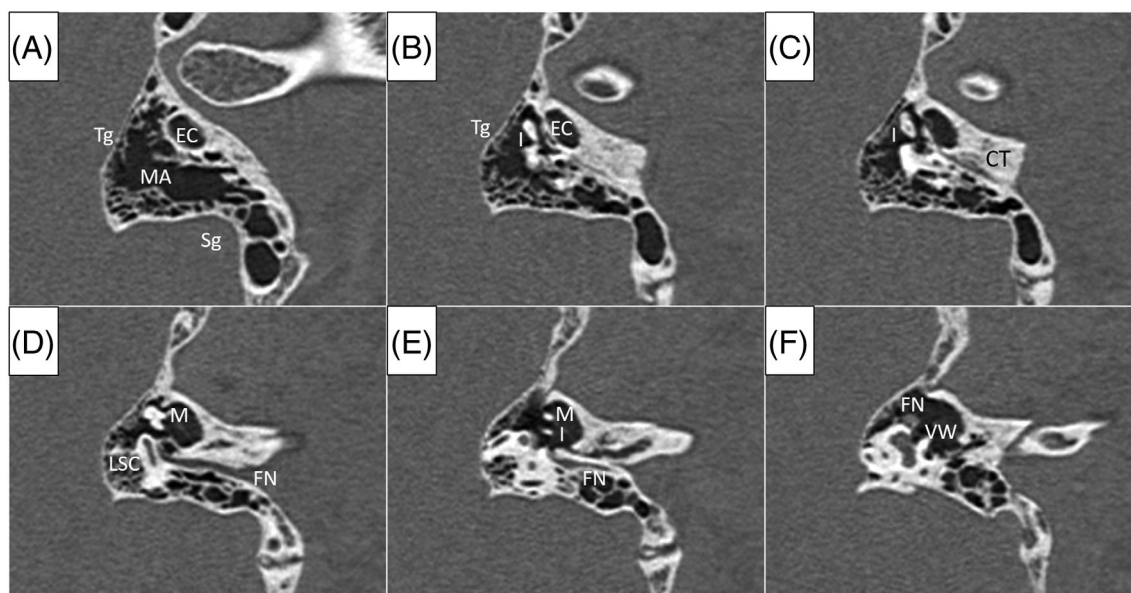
Surgical position view images of the right ear without any lesion (direction: from the outside towards the inside of the temporal bone). EC, external ear canal; Sg, sigmoid vein; MA, mastoid antrum; Tg, tegmen; I, incus; CT, chorda tympani; M, malleus; FN, facial nerve; LSC, lateral semicircular canal; VW, vestibular window. A, The external ear canal is surrounded by the mastoid antrum and the mastoid cell in three directions. This image shows the position of the tegmen and the sigmoid vein. B, The short process of incus is detected in the attic. C, The iter chordae posterius, including the chorda tympani, is drawn. D, The vertical portion of the facial nerve and the lateral semicircular canal are shown. E, Malleus body and the long process of incus line up. F, The horizontal portion of the facial nerve runs in front of the vestibular window
